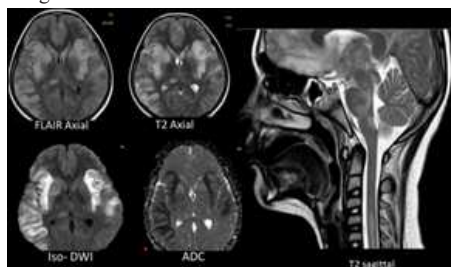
Case of a 13-year-old male patient with Acute Disseminated Encephalomyelitis (ADEM), MRI shows extensive areas of T2/FLAIR hyperintensities involving the bilateral parieto-occipital lobes, with a few areas showing diffusion restriction. Additionally, there are T2/FLAIR hyperintensities involving the bilateral insular cortex and basal ganglia. The T2-weighted sagittal image reveals hyperintensities in the brainstem and cervical spinal cord.
